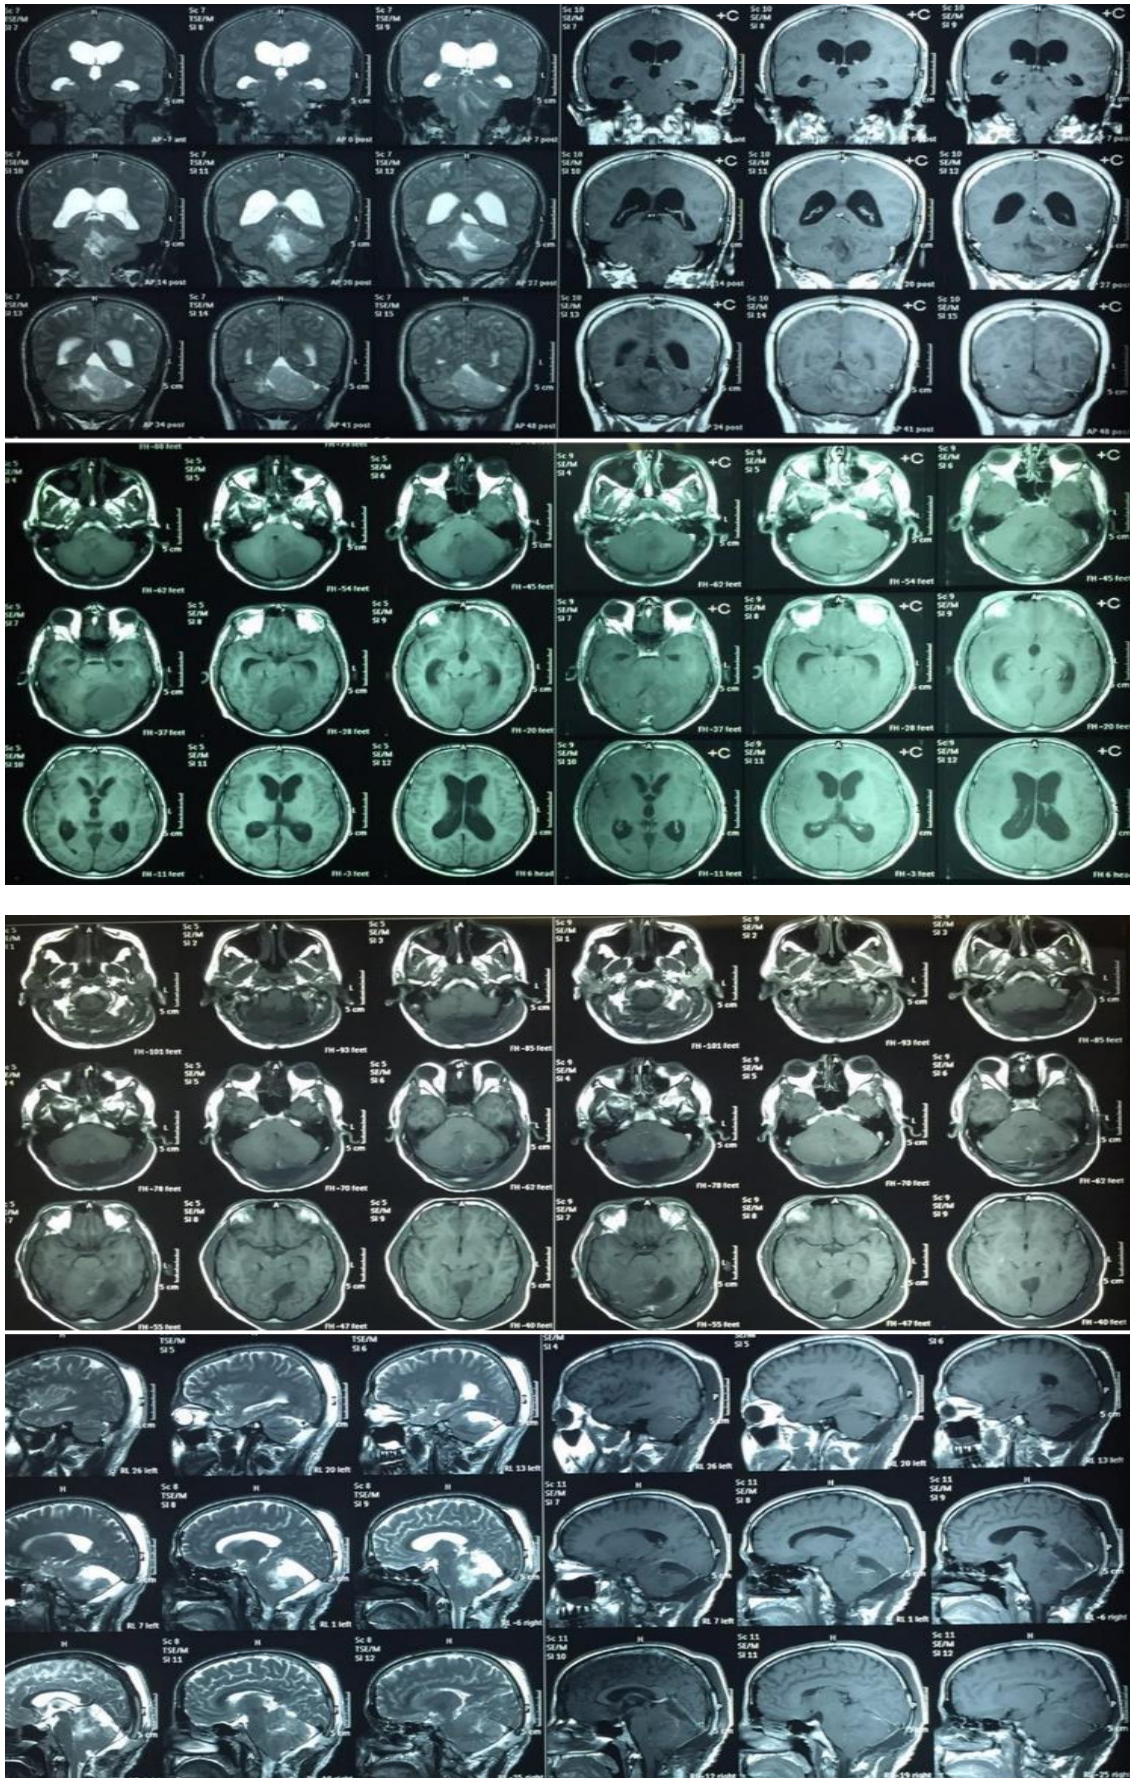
Pre and postoperative MRI shows complete removal of left cerebellar space occupying lesion.
